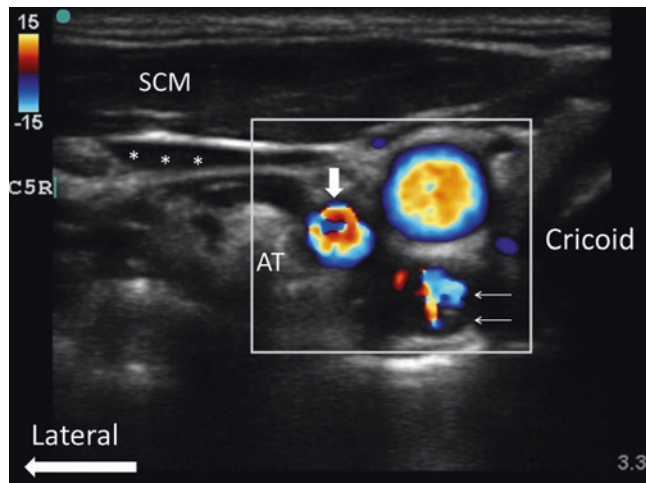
Ultrasound image of the neck at the seventh cervical vertebral level (C7) with Doppler imaging. *Va* vertebral artery, *Ca* carotid artery, *LC* longus colli muscle, *SCM* sternocleidomastoid muscle, * internal jugular vein (compressed), solid bold arrow vertebral artery, line arrows artifact secondary to the shadowing of the carotid artery. Reproduced with permission from Philip Peng Educational Series
